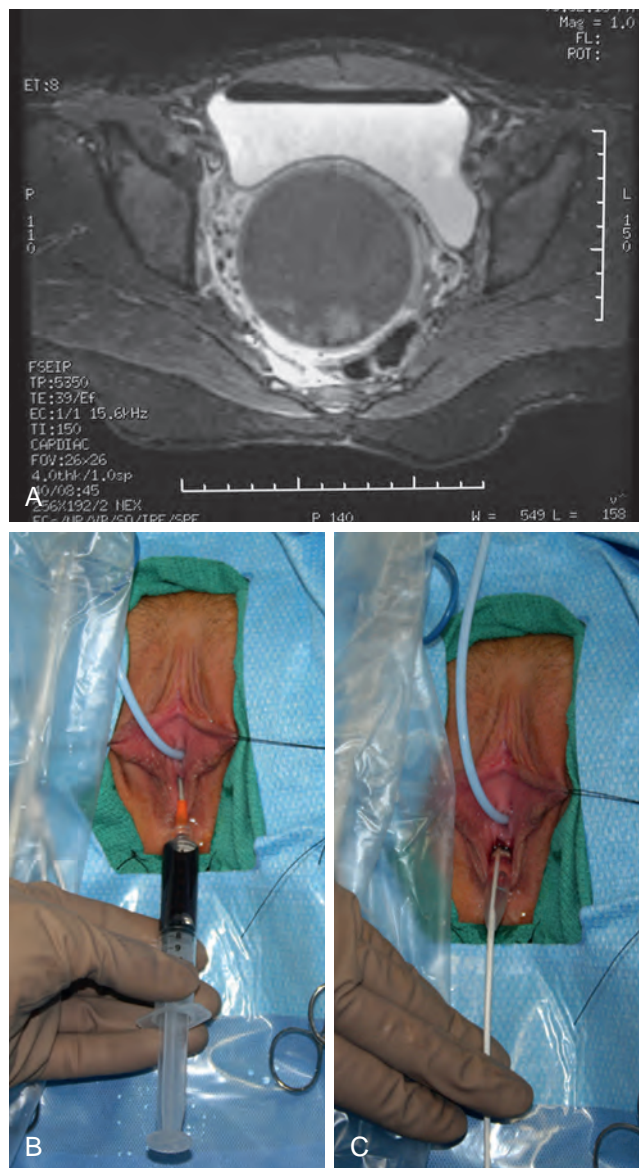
Balloon-assisted division of transverse vaginal septum. A, Hematocolpos on magnetic resonance imaging resulting from transverse vaginal septum. B, Angiocatheter placed into transverse vaginal septum (placed under ultrasound guidance). C, NephroMax balloon dilating the septum.
